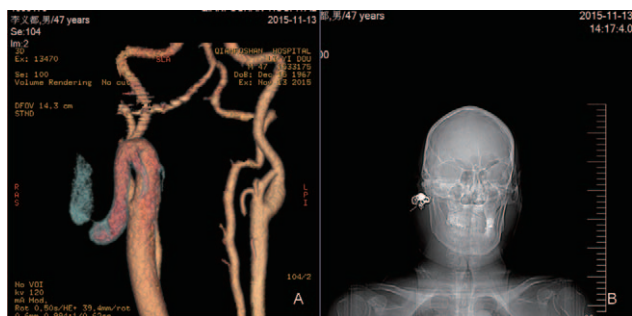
(A) Computed tomography angiography revealed little contrast media in ascending branch of U-shaped loop while orificium fistulae is out of visualization, and there was only one effective ligature in the loop. (B) The mass of detachable coils was over the neck of condyle.
